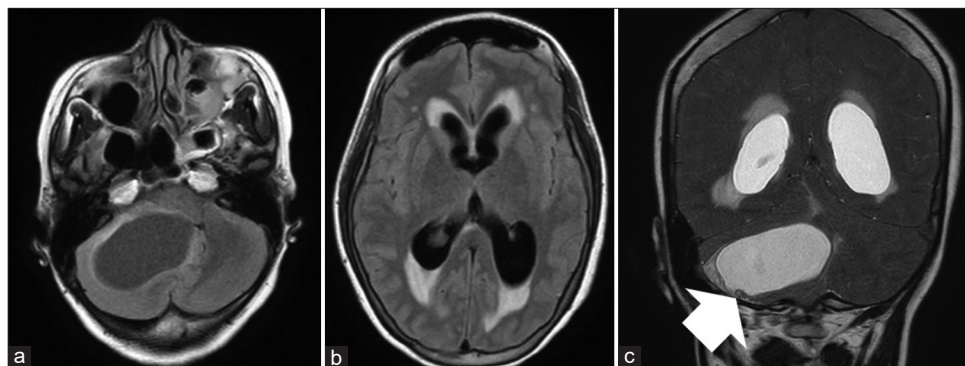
Preoperative FLAIR axial imaging showing a 5.6 cm cystic lesion in the right cerebellar hemisphere, with the lesion draining the fourth ventricle and brainstem, resulting in obstructive hydrocephalus (a and b). T2 coronal image showing a mural nodule in the cyst (white arrow) (c).
